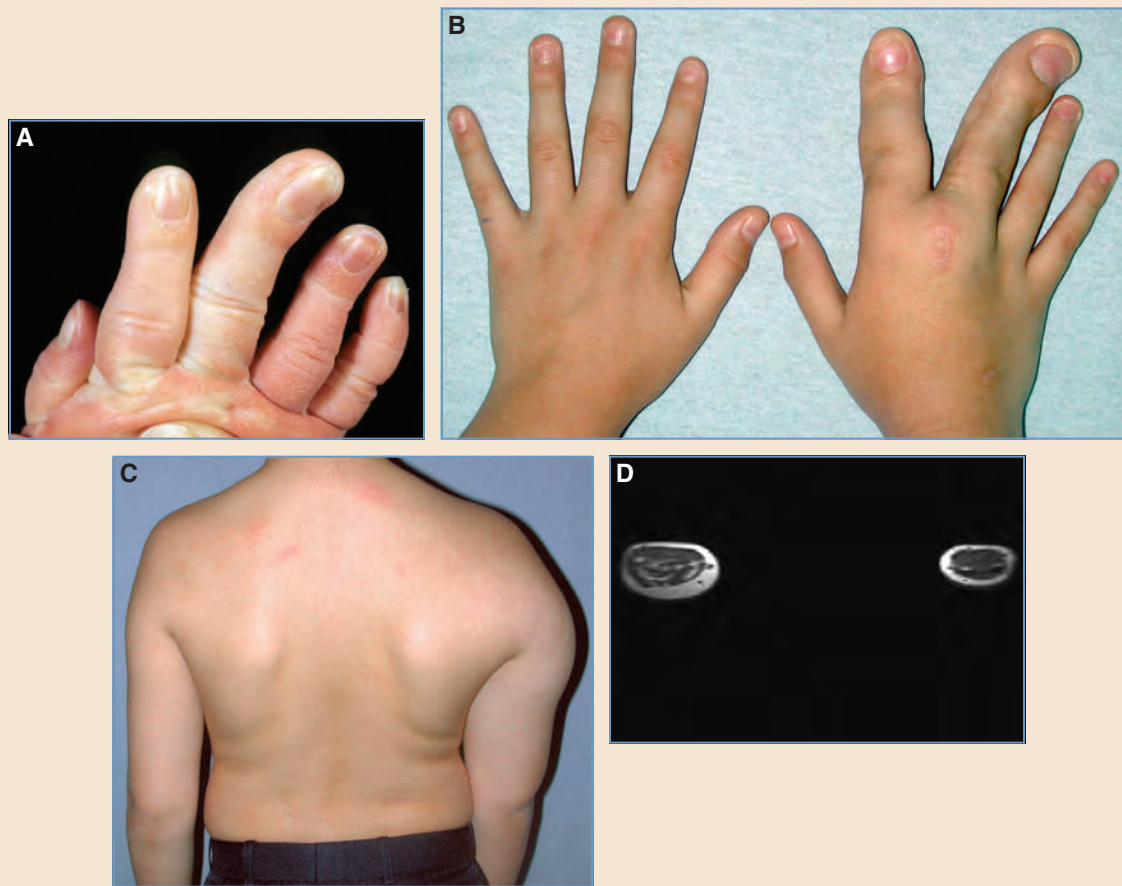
A patient with macrodactyly of the right index and middle fingers and Proteus syndrome. A, At 2 months of age, other stigmata of Proteus syndrome are not yet evident. B, The patient is shown at 13 years of age after three operations to reduce growth and correct angulation; the clinodactyly has partially recurred. C and D, Other manifestations of Proteus syndrome are evident at 13 years of age, including a right arm lipoma that was first noticed at 3 years of age. A T1 MRI at the midforearm level shows increased subcutaneous fat in the right upper limb.
